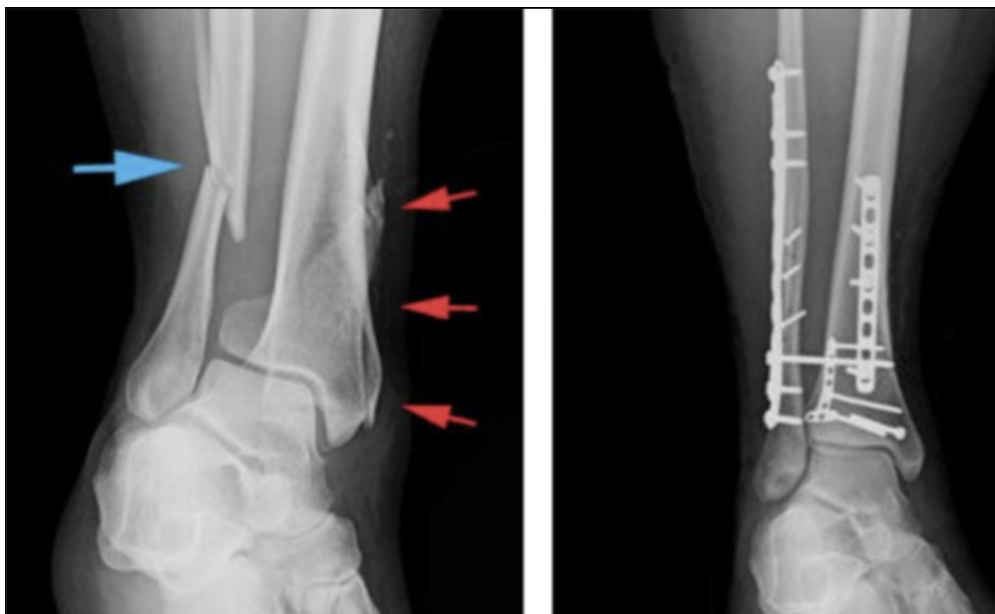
X-ray images showing fractures in the fibula and tibia shafts treated with plates and metal pins inserted into the plate frame to stabilize and realign the bone.
